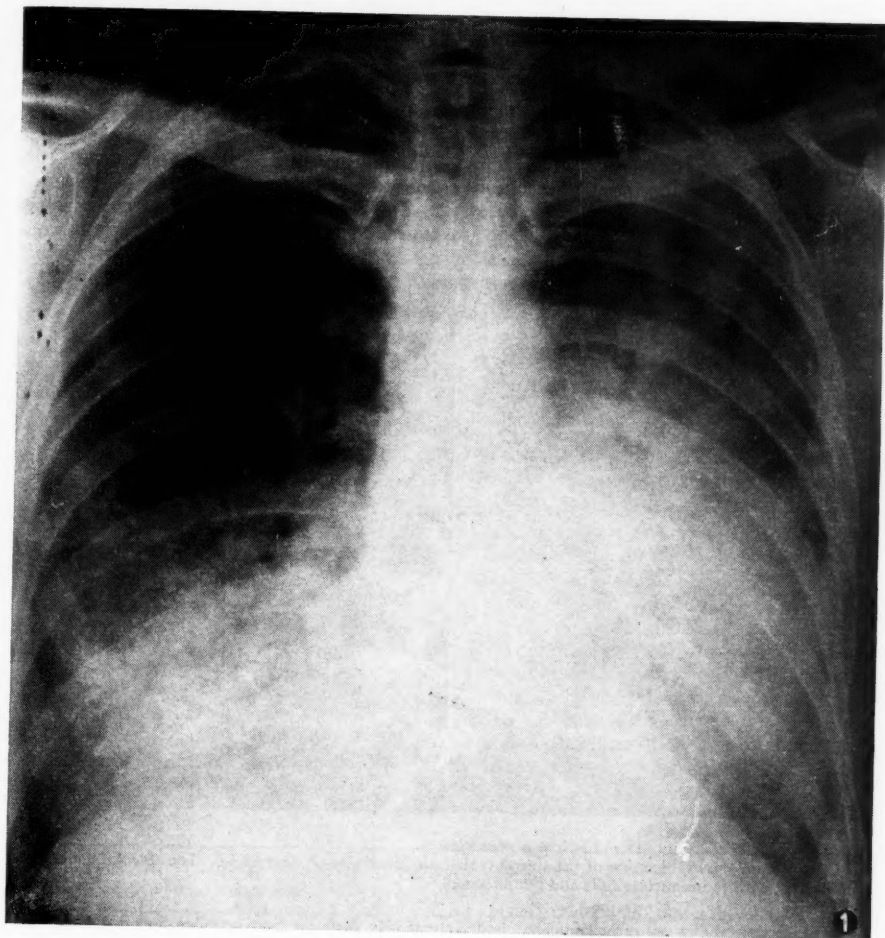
Mr. C. B. X-ray of chest on final admission.
